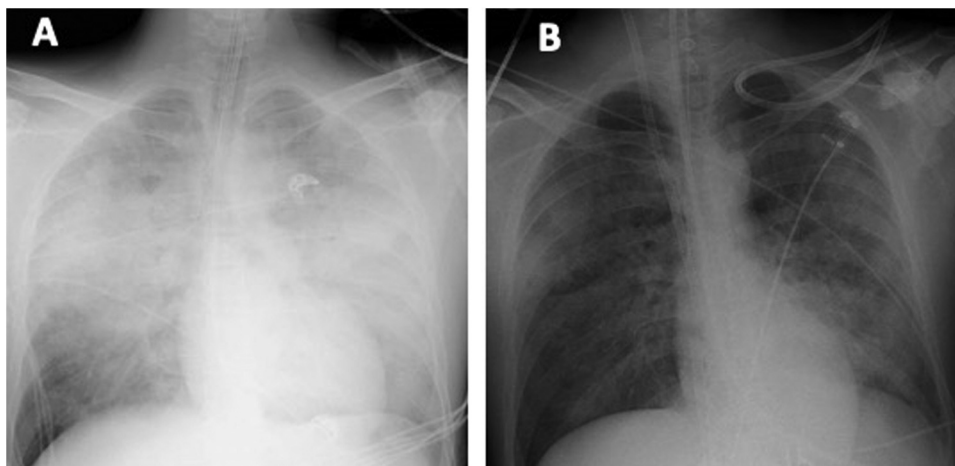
Posterior-anterior chest X-ray at the intensive care unit admission showing severe alveolar oedema (A) and under extracorporeal life support one day after the addition of intra-aortic balloon pump (B).
